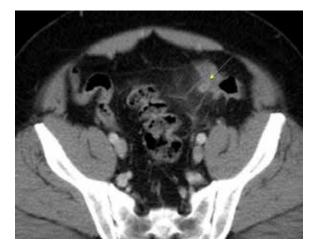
Contrast enhanced CT reveals thickening and enhancement of diverticular wall (arrow) at sigmoid colon with adjacent fat stranding, consistent with Hinchey class I.
